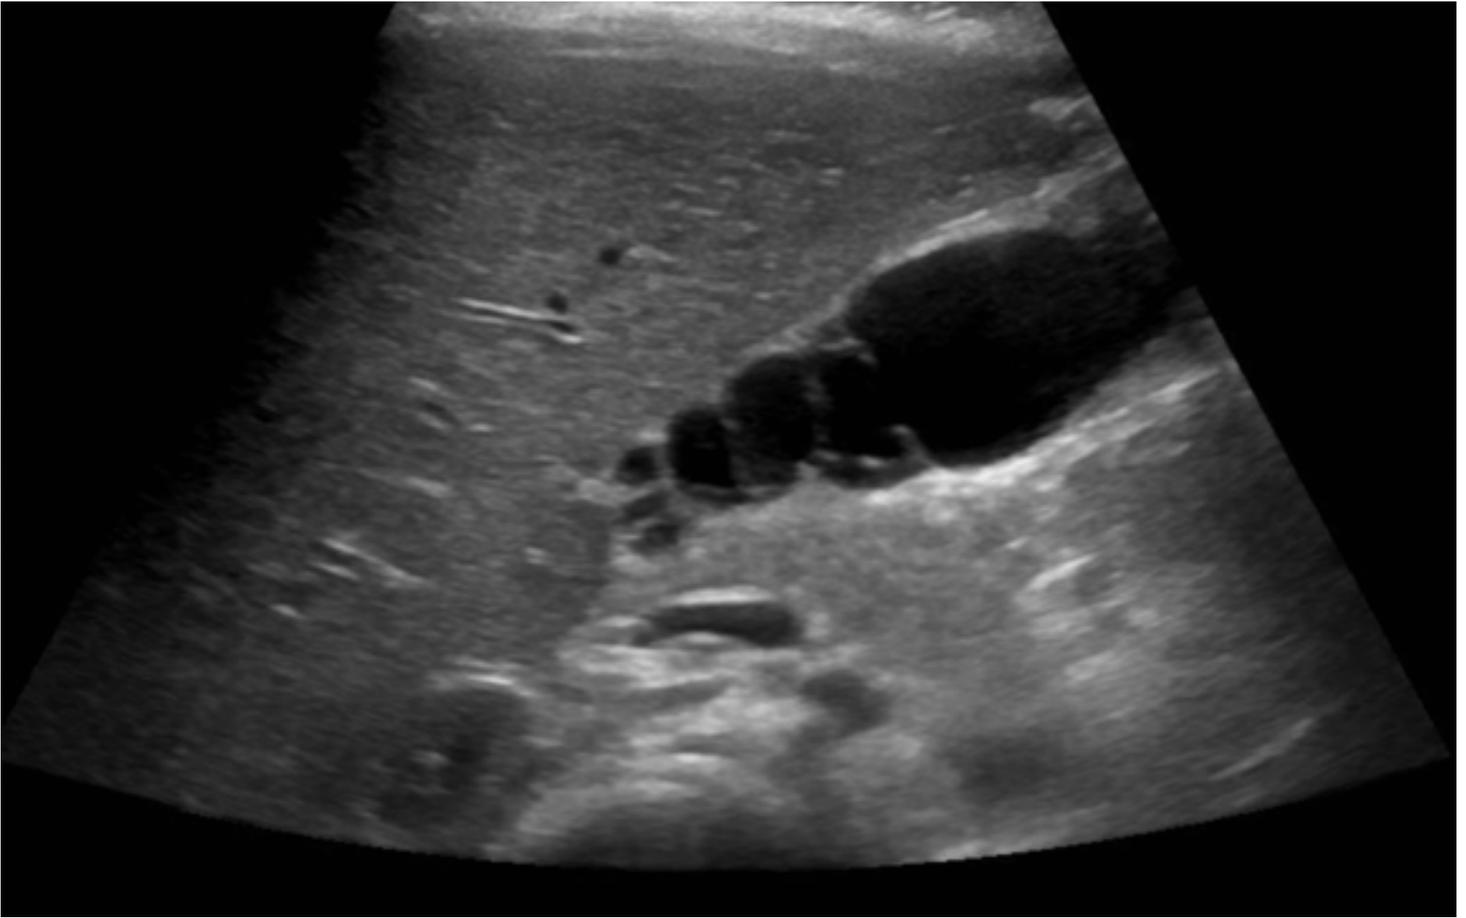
(page 10). Ultrasound of MSG showing multiple thin internal septations with a honey-comb appearance
